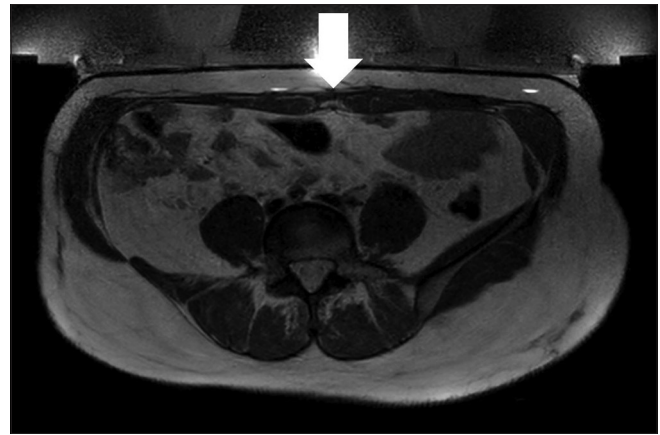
Axial T2-weighted image shows an absence of hyperintense endometriosis lesion inside the right rectus abdominis muscle (white arrow) along with a reduction of lesion size compared to axial T2-weighted image features prior to the treatment
